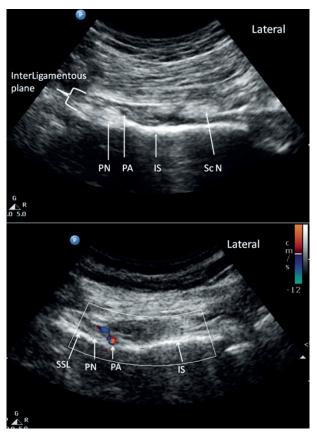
(A) Ultrasound image of the interligamentous plane at the ischial spine where the pudendal artery and nerve are located between the sacrospinous and sacrotuberous ligaments. (B) Color Doppler of the same picture showed the pudendal artery. Reprinted with permission from Philip Peng Educational Series
